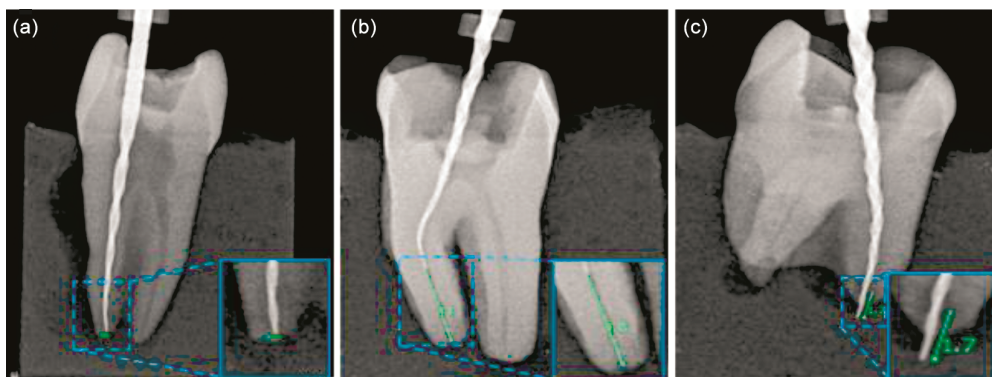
Radiographic images analysis after the dimensional measurement (a) perfectly RCT, (b) apical extent, and (c) beyond apical
